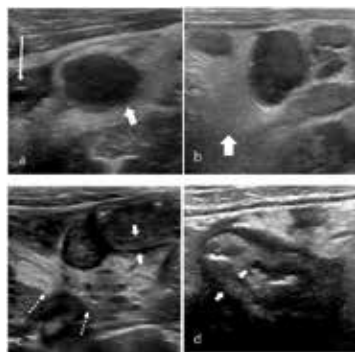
The ultrasound features of right iliac fossa inflammation in four children (a) 7-year-old boy with MIS-C and abdominal pain. High-frequency sonographic image depicts an enlarged mesenteric lymph node within the right iliac fossa (wide arrow), with associated hyperechoic mesenteric fat. The appendix is normal in diameter (thin arrow). (b) 15-year-old boy with MIS-C. Multiple mesenteric lymph nodes within the right iliac fossa, the short axis diameter of the largest lymph node measured 13mm (calipers), with associated hyperechoic mesenteric fat (arrow) were noted on US. (c) 9-year-old boy with MIS-C. US shows loops of thickened small bowel (between solid arrows) with associated hyperechoic mesenteric fat (dotted arrows). (d) 16-year-old boy with severe right iliac fossa pain. High-frequency sonogram shows marked cecal wall thickening (arrows).
